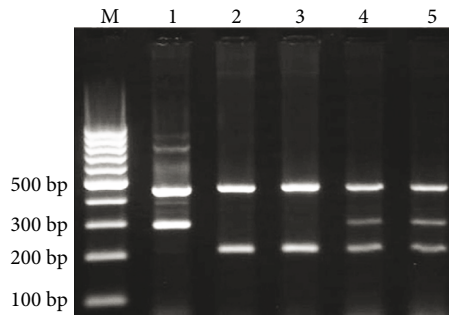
Electrophoresis pattern of T-ARMS-PCR for detection of apelin rs2235306 polymorphism. In the T-ARMS-PCR method, 2 external primers (control band) and 2 inner primers (allele specific primers) are used. The product sizes were 208 bp for T allele, 295 bp for C allele, and 458 bp for control band. M: DNA Marker; Lane 1: rs2235306 CC; Lanes 2, 3: TT; Lanes 4, 5: CT.
